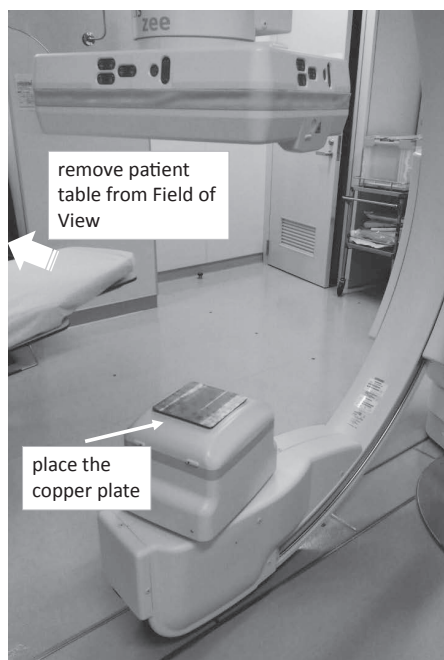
An example of geometric arrangement for X-ray output check
